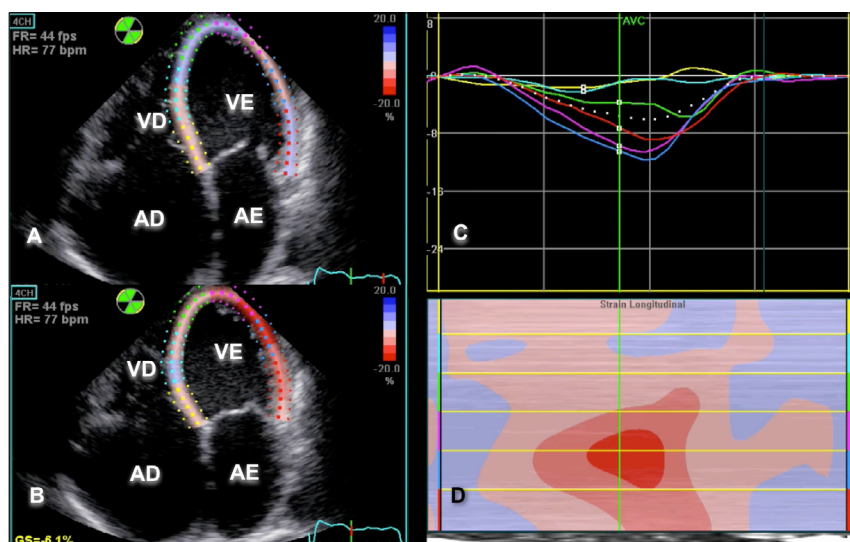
ECHOCARDIOGRAM OF PATIENT WITH CLINICAL HF AND PRESERVED LV EJECTION FRACTION
